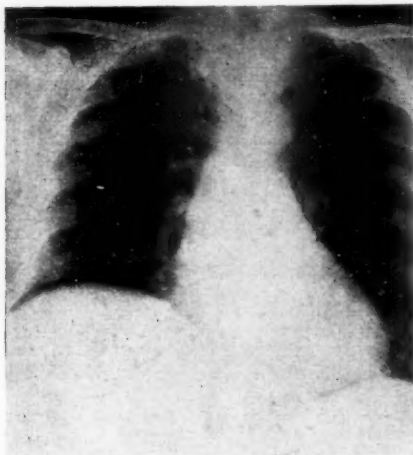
Pre-operative X-ray to show splaying of ribs and raised diaphragm.
